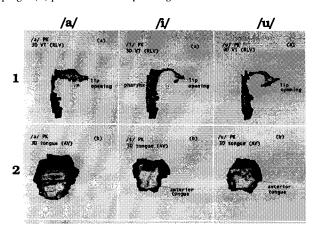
MRI data for vowels /a,i,u/ of a female subject (PK). (1) 3D vocal tract images, lip opening toward the right of each panel (2) Anterior view of 3D tongue shapes, tongue tip toward the bottom of each panel.
